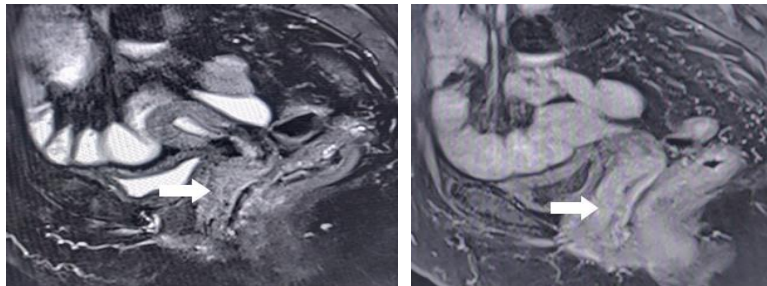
depicts lesion involving the cervix and lower uterine body with parametrial and UB invasion. Hyperintense thickening of the bladder mucosa at T2-weighted imaging indicates edema and is not a direct sign of invasion. The “bullous edema sign” of the posterior wall mucosa needs careful analysis for assessment of any associated tumour nodules.<sup>[6]</sup>
